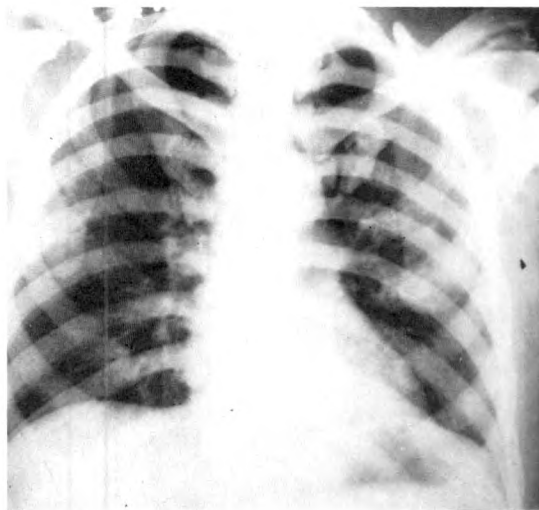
Posteroanterior chest roentgenogram shows the typical, but not so extensive, changes of sclerosis.
